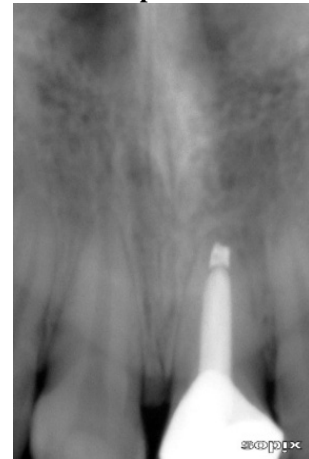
Normal periapical radiographic appearances at the end of 2 year follow up.
